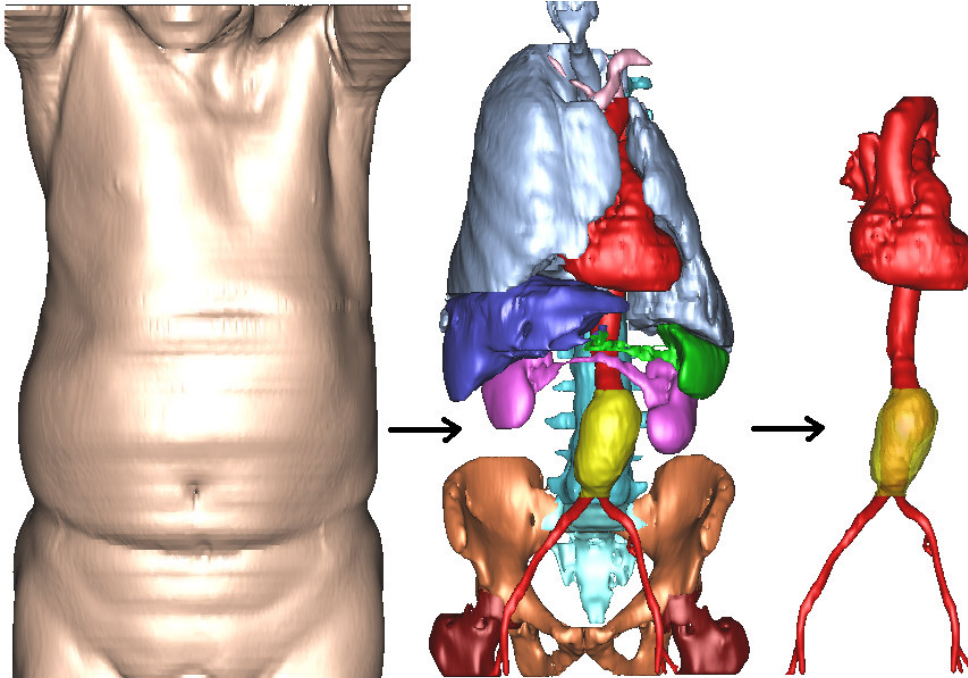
Full 3D reconstruction of CT scan data set. Image shows the use of layers to highlight/remove particular regions of interest depending on desired areas.
